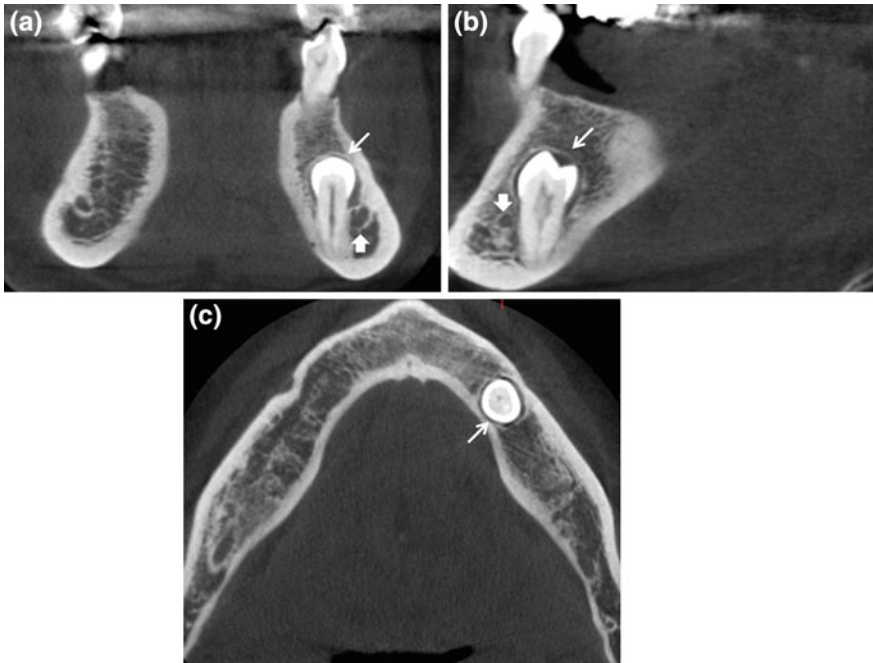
CBCT coronal (a), sagittal (b) and axial (c) sections showing impacted 35 tooth (*thin arrow*). Note the vertical orientation and the thin radiopaque layer around the crown (follicular space). Impacted premolar is placed on the lingual side of the mandibular canal (*arrow*)
